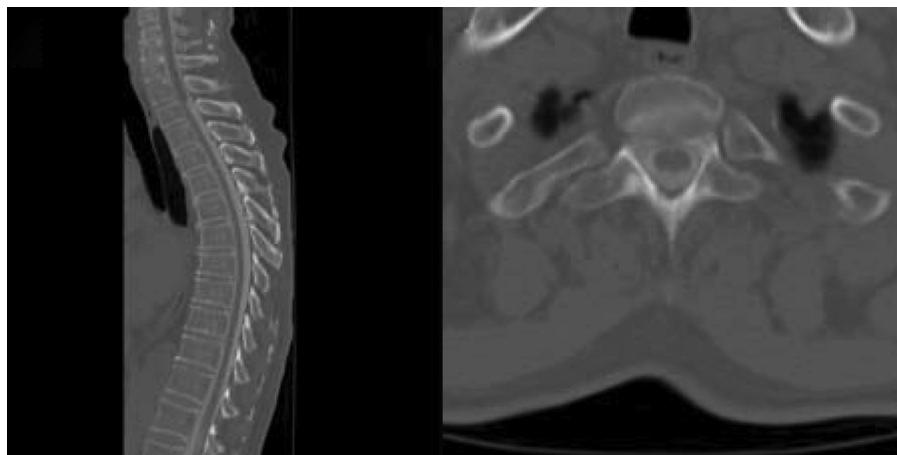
(Left) Sagittal and (Right) axial computed tomography myelogram images concerning for an obstructive membrane at the level of the superior end plate of T2.
